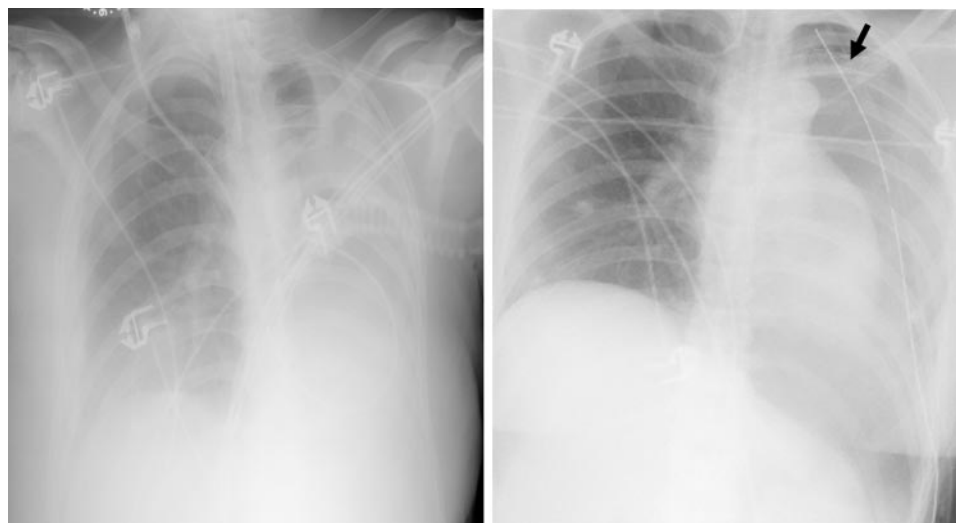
Chest radiograph showing left-lung opacification (pneumectomy), before (left) and after (right) left-chest-tube placement. The arrow points to a left-subclavian-vein stent.
